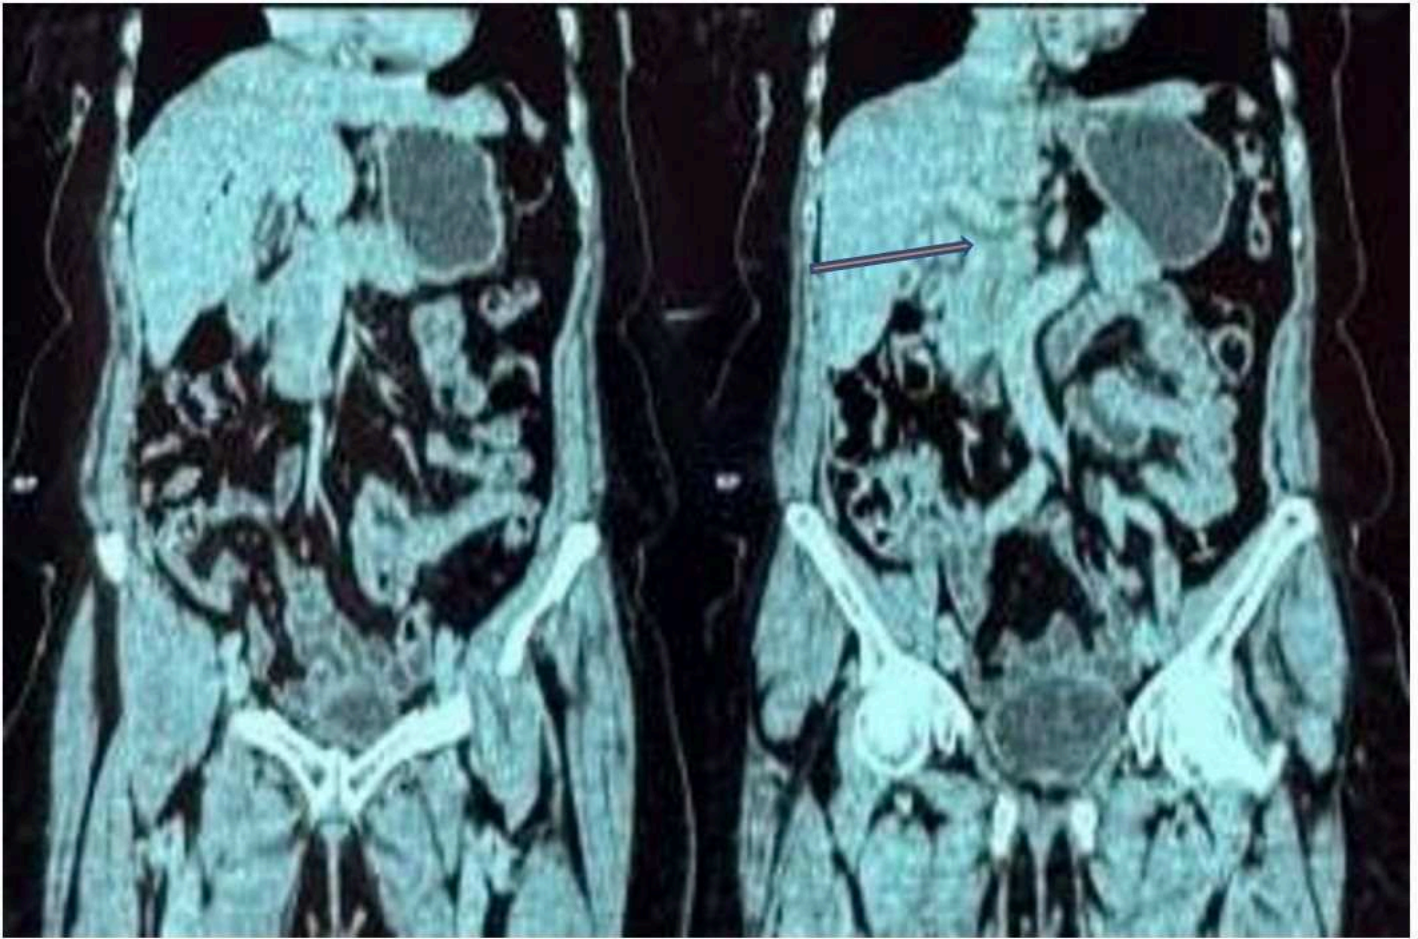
CT scan images showing dilated CBD. Arrow shows the dilated duct.
